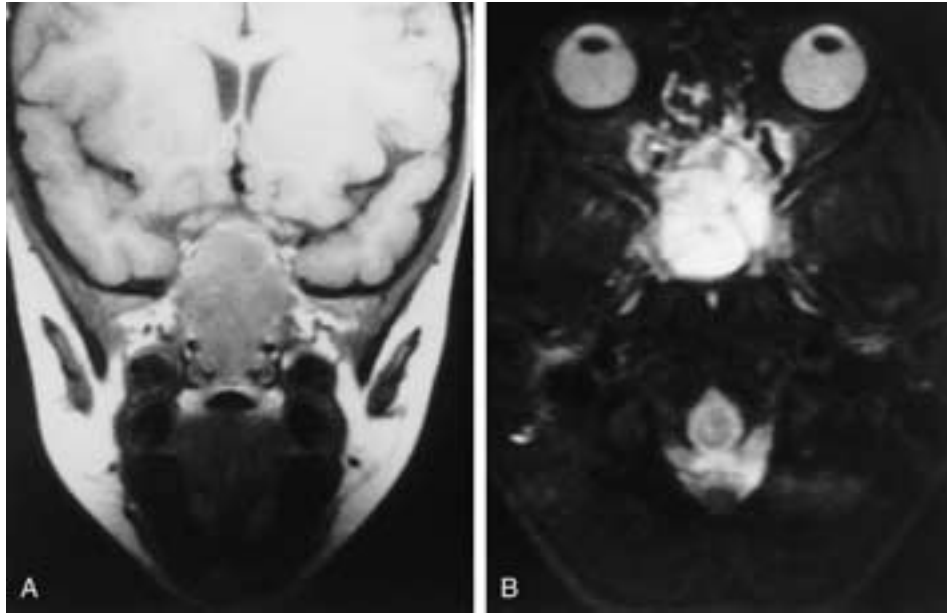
Six-year-old female with rhabdomyosarcoma of the nasopharynx invading the skull base and sphenoid sinus. A, Coronal T1-weighted MR image demonstrates a mass extending into the sphenoid sinus and posterior ethmoid air cells. The mass extends upward to involve the planum sphenoidale. B, Axial T2-weighted MR sequence demonstrates diffuse homogeneous increased signal intensity. Intensity is nonspecific. Rhabdomyosarcoma must be included in the differential diagnosis along with nasopharyngeal lymphoma and squamous carcinoma in a young patient with a nasopharyngeal mass.
